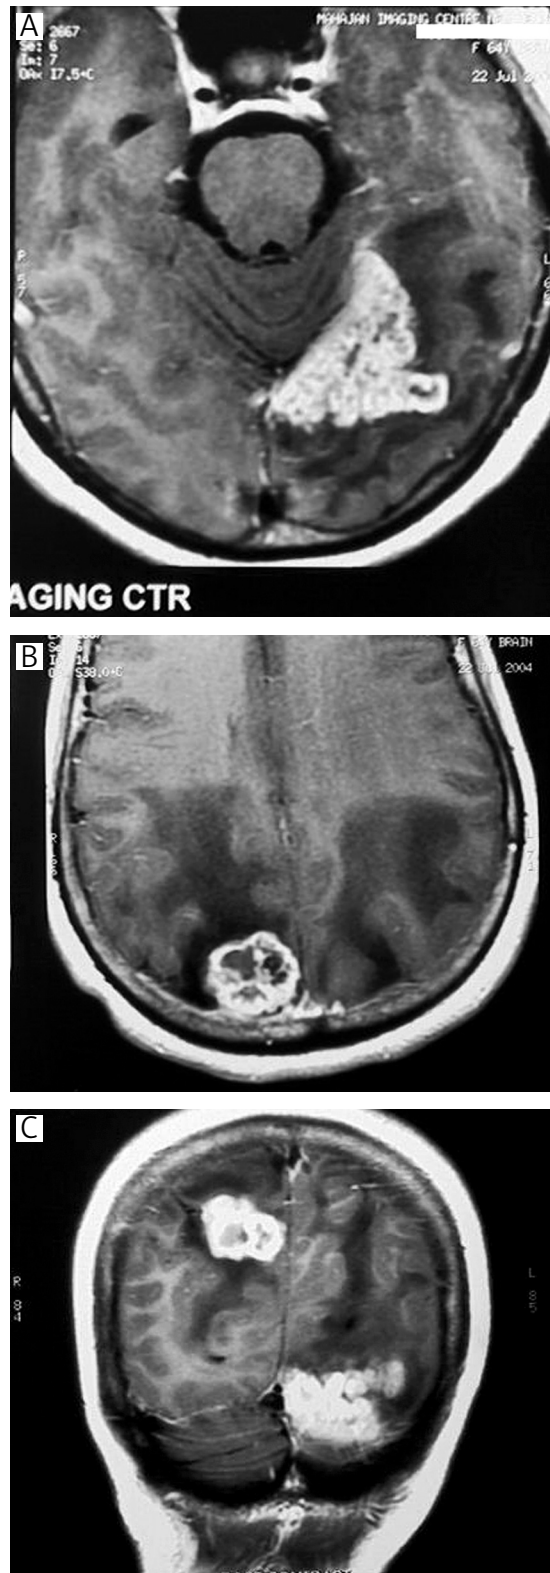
MRI of the brain showing ring enhancing solitary lesions in the left frontal lobe and conglomerate ring enhancing masses in the left and right temporooccipital region with surrounding vasogenic edema
